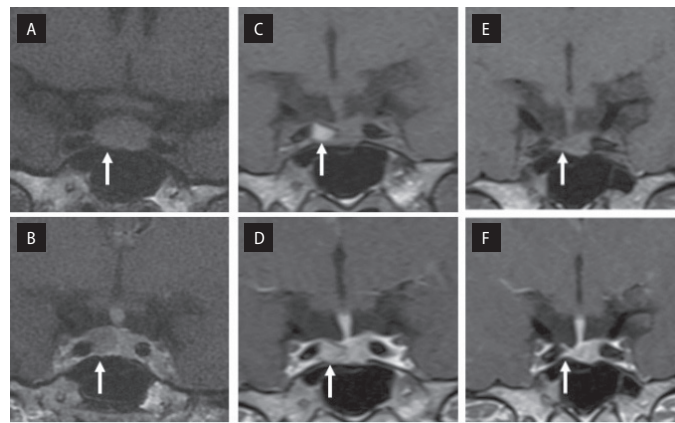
Magnetic resonance images (MRI). Coronal T1-weighted pre-contrast (A, C, E) and (B, D, F) post-contrast. A, B. An initial picture of the microadenoma — an isointense, homogeneous 8 mm focal lesion located on the right side of the enlarged pituitary gland (14 × 11.3 × 10.4 mm) with delayed contrast enhancement (white arrows) and the pituitary stalk slightly deviated to the left; C, D. At admission to the Department of Endocrinology (DE) — haemorrhage region in the microadenoma (size 6 × 5 mm) with hyperintense pre-contrast and post-contrast signals within the focal lesion (white arrows); E, F. Twelve months after pituitary apoplexy (PA) — complete regression of the microadenoma, resulting in a partially empty sella on the right side, in the location of the previously described lesion (white arrows)
